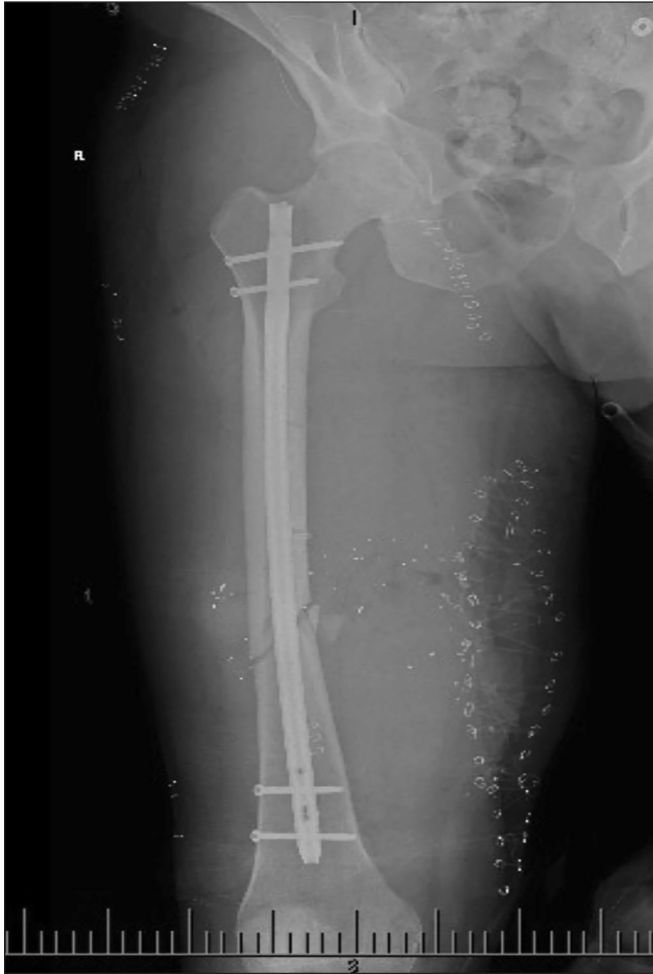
Preoperative radiograph showing a comminuted fracture of the right femur and shrapnel from the ballistic injury. The medial aperture is marked with a metallic paper clip.
